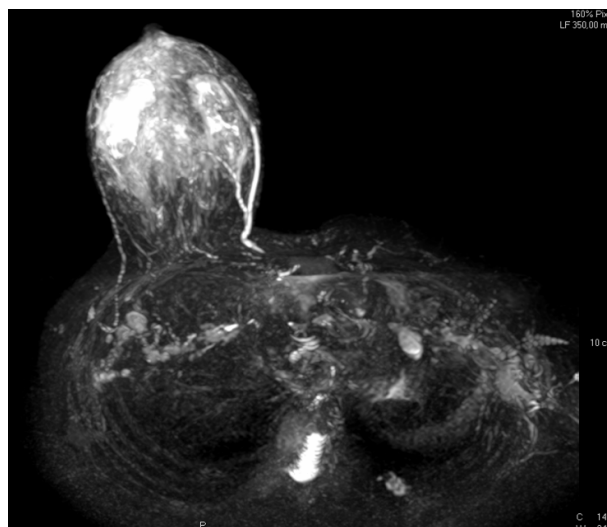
Post medical treatment image of right contralateral breast recurrence after a previous left mastectomy. The MRI shows diffuse enhancement in different areas. Mass lesions, non-suggestive of a specific diagnosis, parenchymal inflammation, and remarkable thickening in the mammary skin of the right breast were observed.
